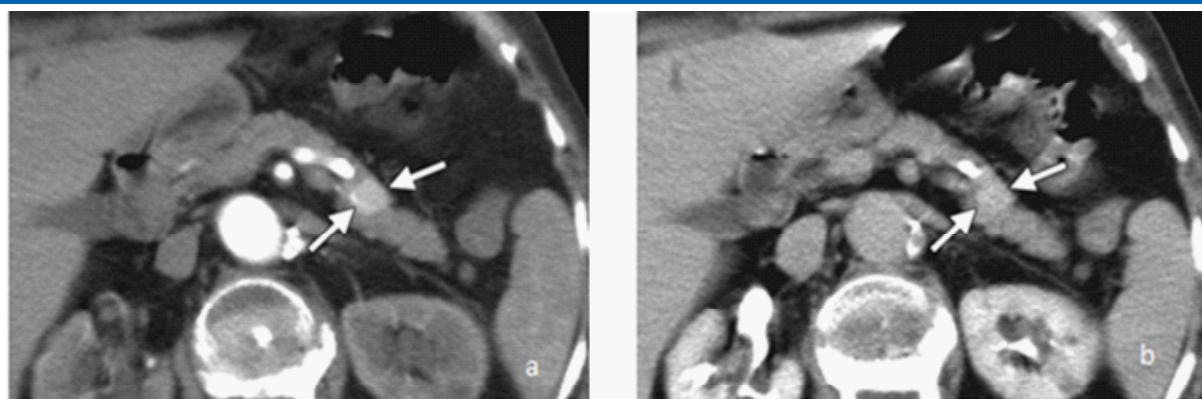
Axial contrast - enhanced CT images obtained in the arterial phase (a) and late venous phase (b) show a 1.5-cm homogeneous hyperenhancing mass at the junction of the pancreatic body and tail (arrow), The mass is more conspicuous on the arterial phase image than on the venous phase image.
